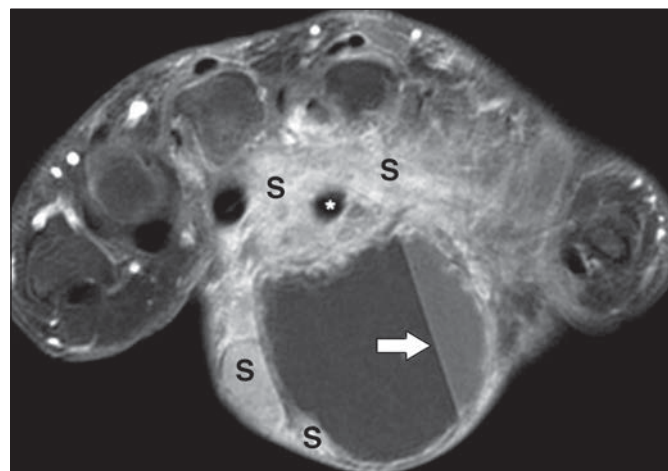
9-year-old boy with epithelioid sarcoma presenting as acute swelling of slow-growing lump in hand. A, High-resolution ultrasound image of hand mass shows multiseptate mass (arrows) with deep extension. Locules contain fluid (F) and low-level echoes (asterisks), likely hemorrhage.
